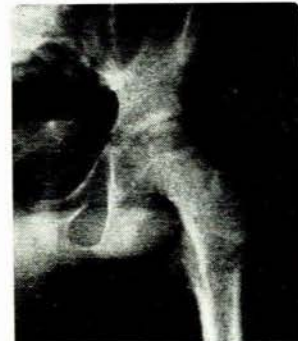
X-ray photo of pelvis and left hip joint (case 1). Note marked ischial erosion and cortical destruction with breakthrough at the iliopectineal line and erosion also of the lateral border of the ileum. The left hip joint space is markedly narrowed with subluxation and destruction of the acetabulum. Note also the intrapelvic soft tissue swelling adjacent to the iliopectineal line.
